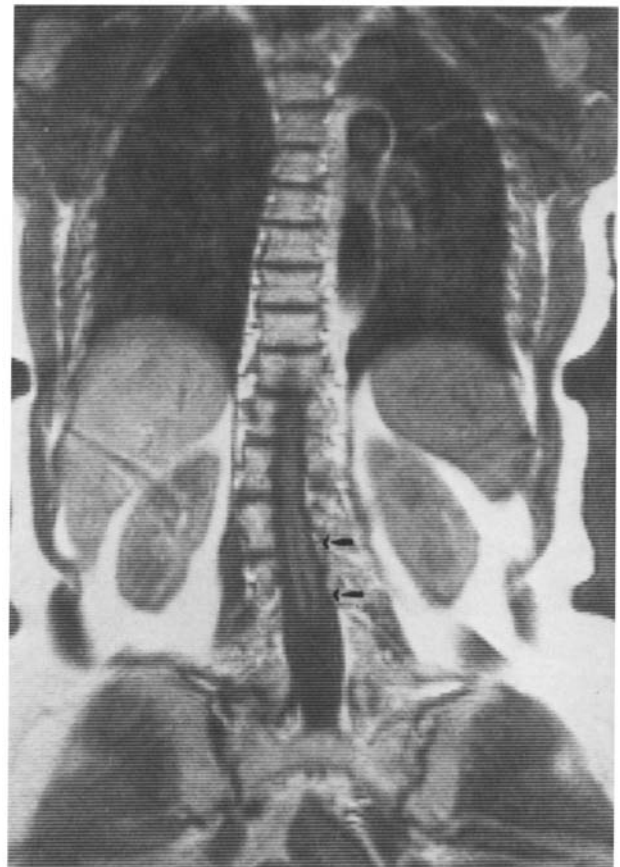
MRI, frontal section, due to the physiological curvature of the spine only the lower parts of the spinal cord are localized in this cut. Diastematomyelia is clearly visible (arrows)
